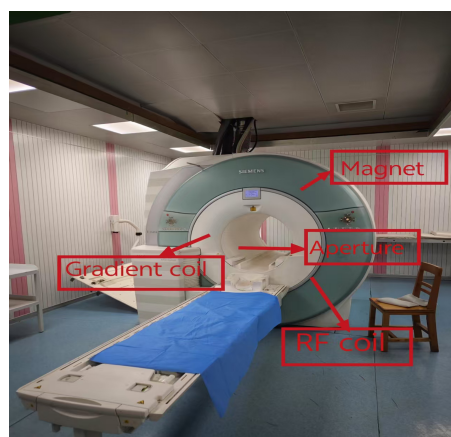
A photo of a certain brand of MRI equipment in clinical practice
